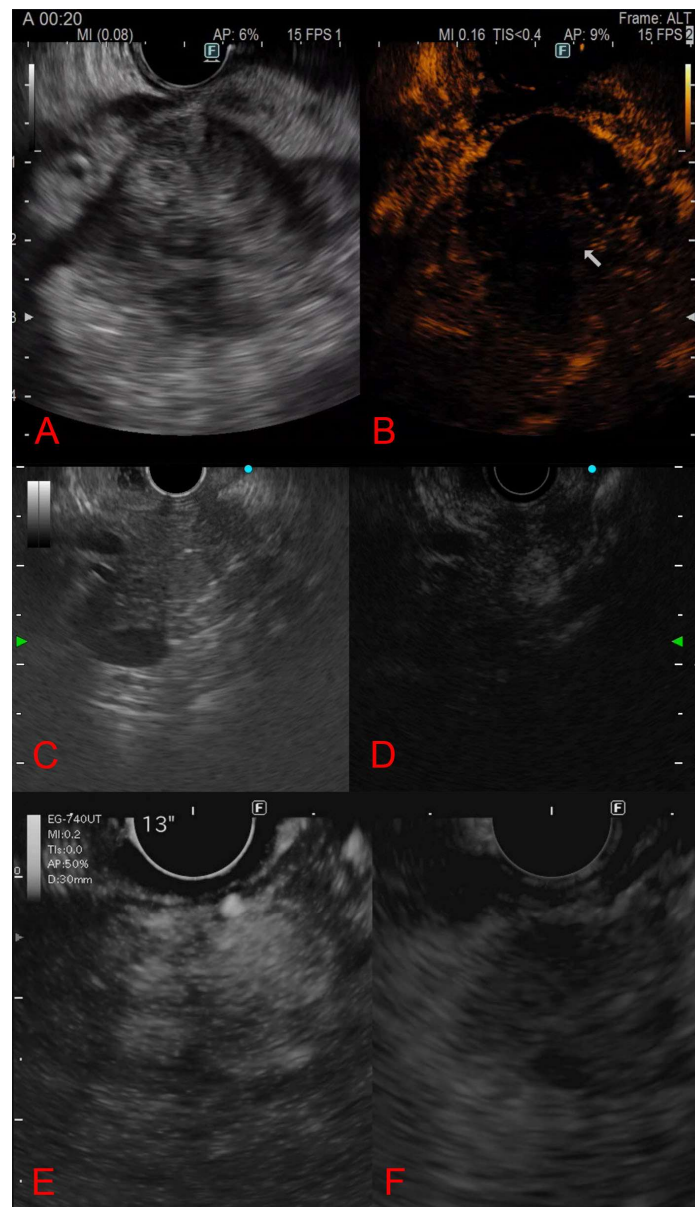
Contrast-enhanced endoscopic ultrasound behavior of solid pancreatic lesions. A-B: Adenocarcinoma (hypoechoic lesion with ipo-enhancement). C-D: Neuroendocrine tumor (hyper-enhancement in arterial phase). E-F: Pancreatic metastasis from renal cell carcinoma (arterial hyperenhancement with heterogeneous distribution).
